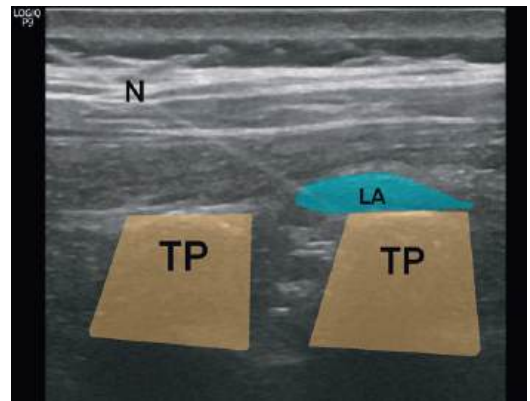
Ultrasonographic image of ESPB at thoracic level 10.
